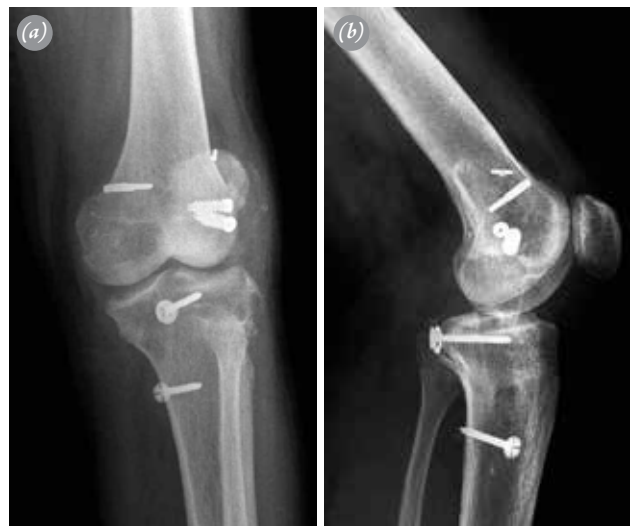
(a) Anteroposterior, (b) Lateral radiographs demonstrating ACL/PCL/PLC reconstruction (postoperative).
